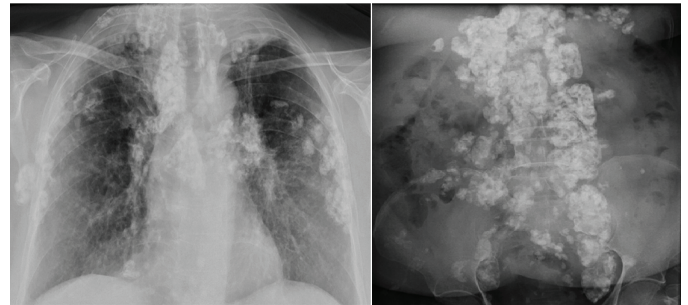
Posteroanterior chest X-ray showed multiple calcified lymph nodes in the mediastinum, cervical region, both hila, and axilla. Plain abdominal X-ray in standing position showed multiple calcified lymph nodes in the paraaortic and parailiac regions.
